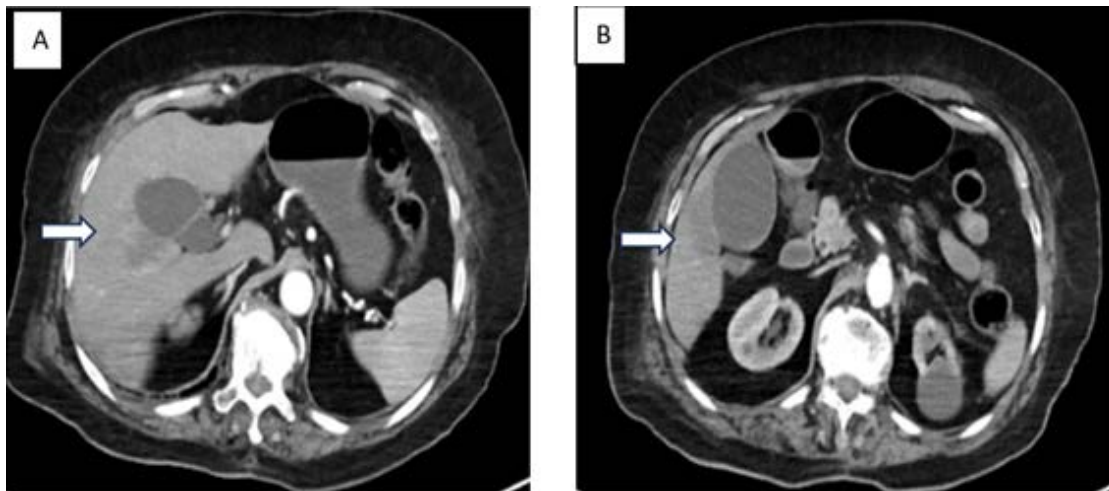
(A-B). A 64-year-old female patient, extracted from under debris and brought to our hospital 32 hours after the earthquake. Due to suspect of solid organ injury, a contrast multidetector computed tomography examination was performed. The obtained images revealed the parenchymal of contusion (white arrow) in the right hepatic lobe.
